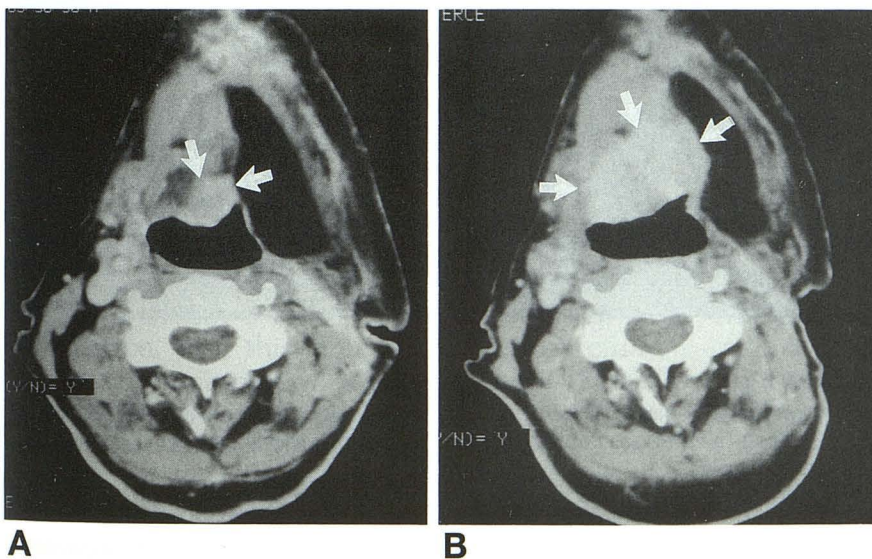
Focal solid recurrence beneath a pectoralis major myocutaneous flap. The solid mass (white arrows) increased in size from the first (A) to the second (B) CT scan, performed 4 months later.
